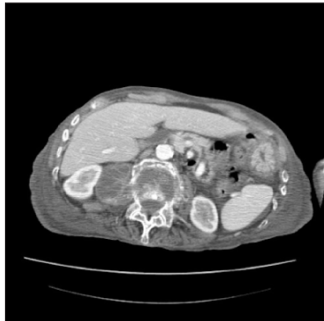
Initial CT scan showing the size of abscess and collapsed L3 vertebrae.
